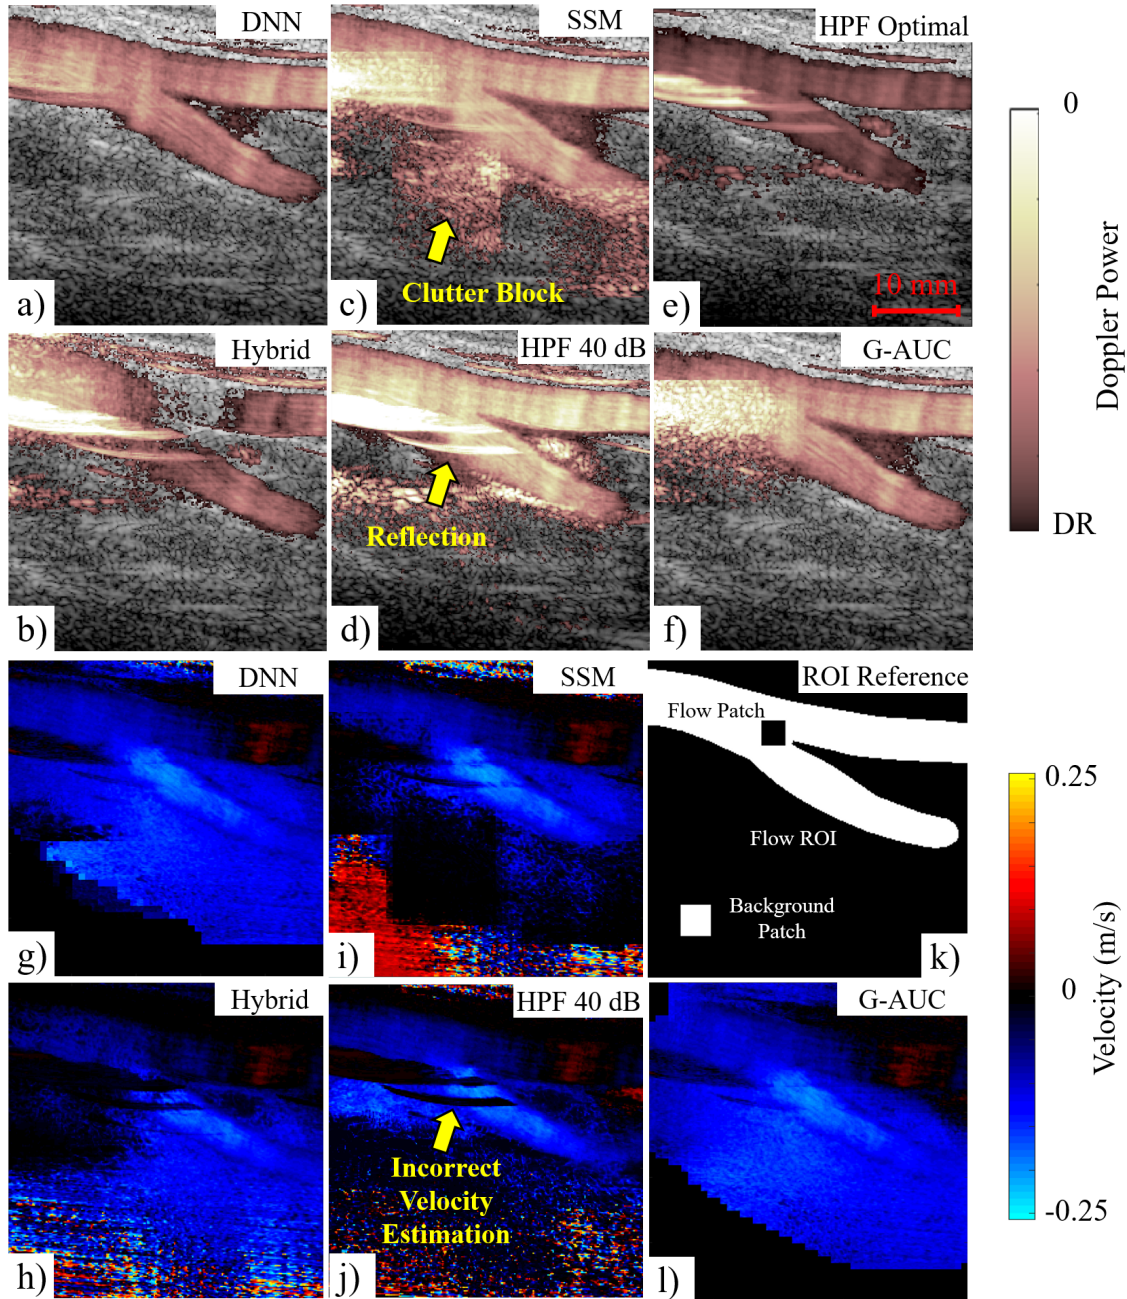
Power and colour Doppler images produced using the clutter filtering techniques described in Table 5 for frame 77 of acquisition F03 where significant tissue clutter is present. *a), g)* The proposed DNN filter. *b), h)* Hybrid method. *c), i)* Spatial similarity method. *d), j)* High-pass filtering under 40 dB dynamic range. *e)* High pass filtering using an ‘optimally’ set 62.2 dB dynamic range relative to the maximum pixel intensity. *f), k)* Ground AUC values (G-AUC). *l)* An example blood region ROI used for AUC calculations and the flow and tissue patch ROIs. All SVD filtered images are presented under 20 dB dynamic range. Only the proposed method was able to robustly identify flow and remove all tissue clutter from the power and color Doppler images.
